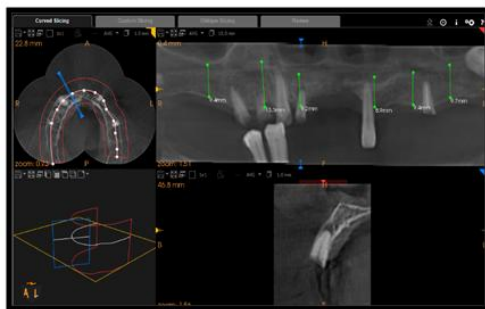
CBCT for Maxillary implants
